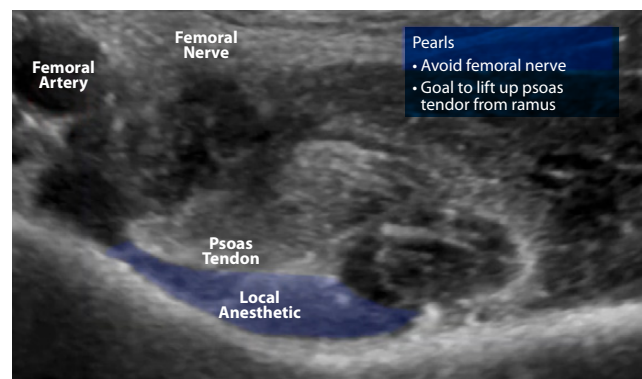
Ultrasound image demonstrating anesthetic lifting the psoas tendon from the pubic ramus, indicating successful anesthetic deposition. The femoral nerve and artery have been avoided.
